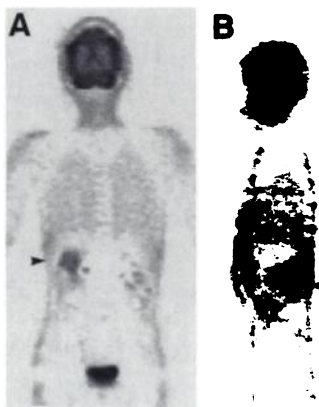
FDG uptake in a *Staphylococcus aureus* abscess of the right kidney (indicated by the arrowheads), coronal (A) and sagittal (B) images.
